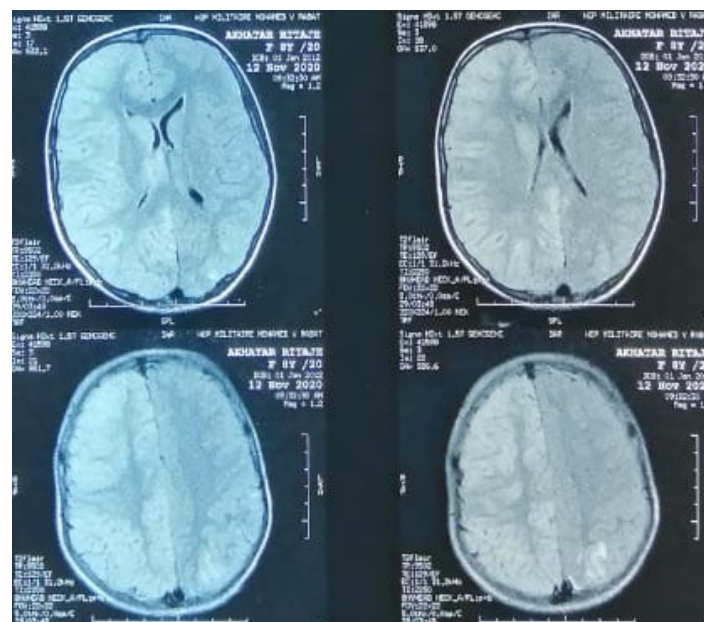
Axial FLAIR-weighted hyperintense signal of the right hemisphere.
